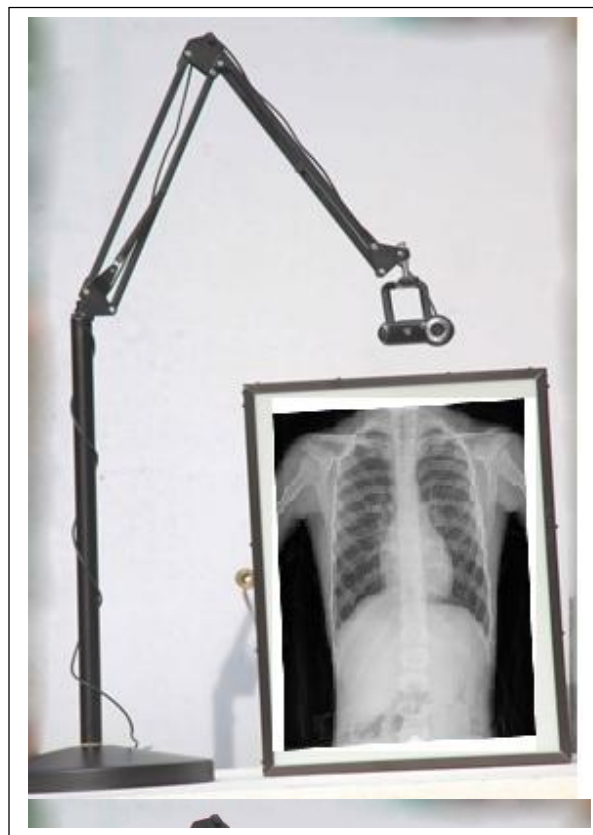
Digital X-ray Viewer
